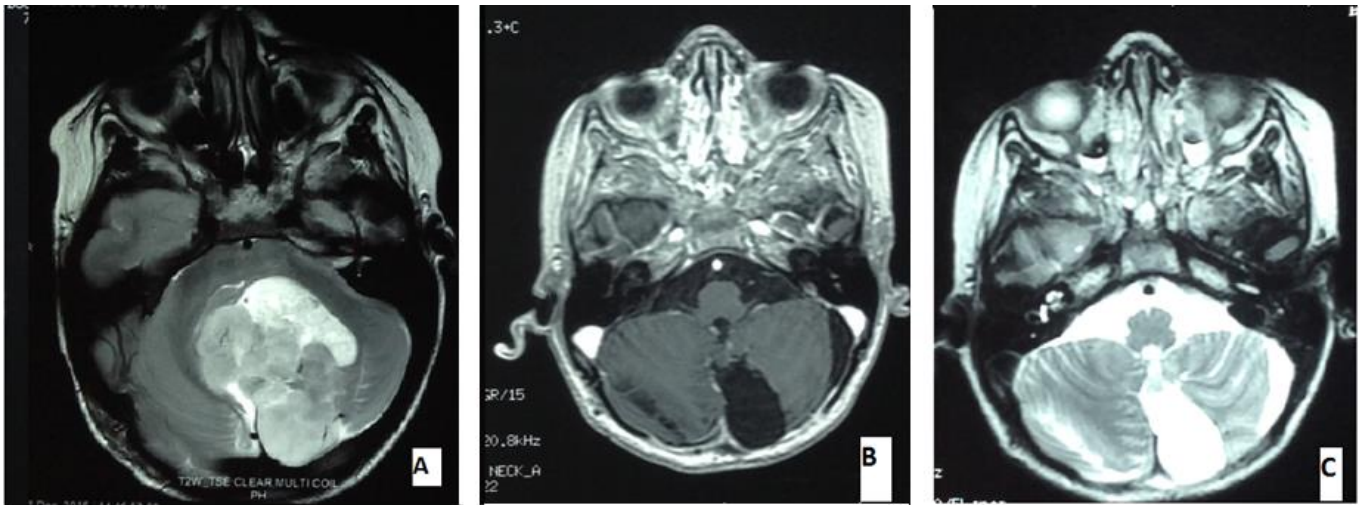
(A) MRI- CT Scan of the brain demonstrating a posterior fossa (Vermian) expansive process, with mass effect on V4. (B, C) Fluid cavity of left cerebellar hemisphere with T1 hypointense and T2 hyperintense signal, not enhanced after gadolinium injection, measuring 24x20 mm corresponding to postoperative modifications and without sign of residual tumor.
